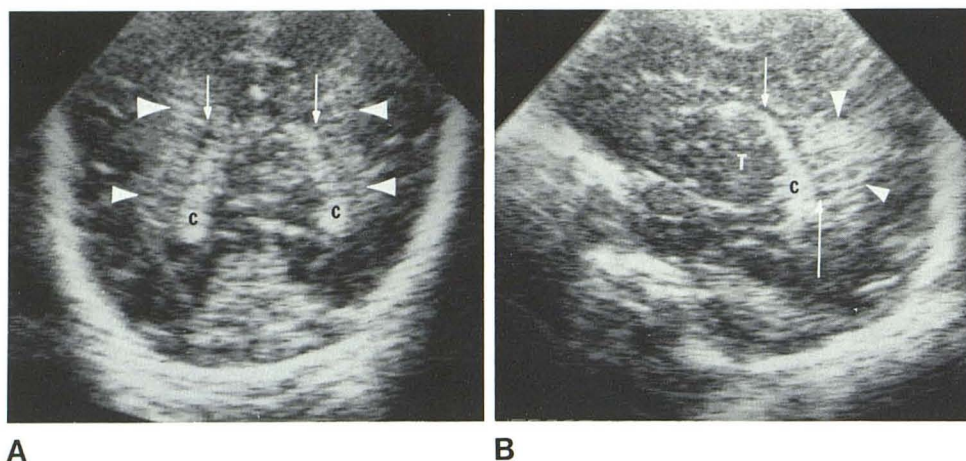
Normal subject. Semiaxial (A) and parasagittal (B) sonograms. Normal periventricular echogenic halo (arrows). Irregular, poorly defined borders. Separation from hyperechoic choroid plexus (C) by thin line of anechoic CSF (arrows). T = thalamus.
